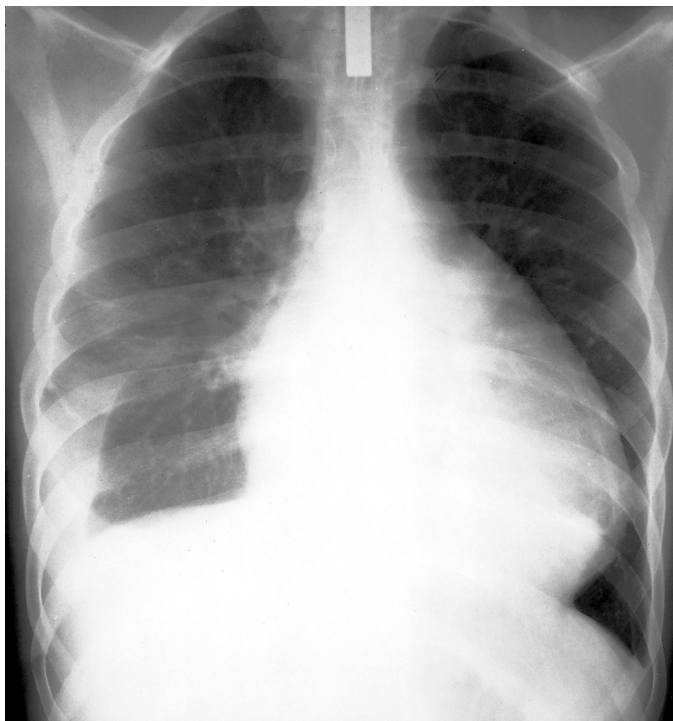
FIGURE e71-2 Anteroposterior chest radiograph in a patient with a large pericardial effusion (see text). (From Kabbani SS, LeWinter M: *Cardiac constriction and restriction*. In Crawford MH, DiMarco JP [eds]: *Cardiology*. St. Louis, CV Mosby, 2001, p 5,15.5.)
